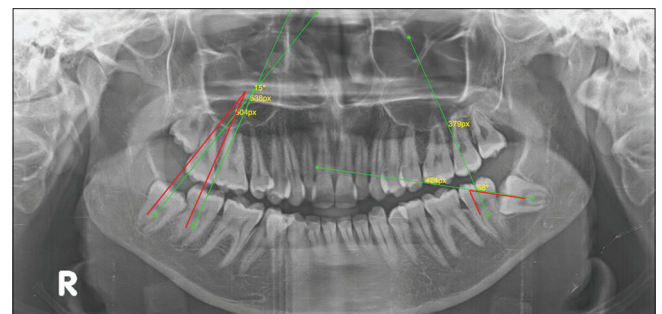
Orthopantomogram showing  $\beta$  angle
